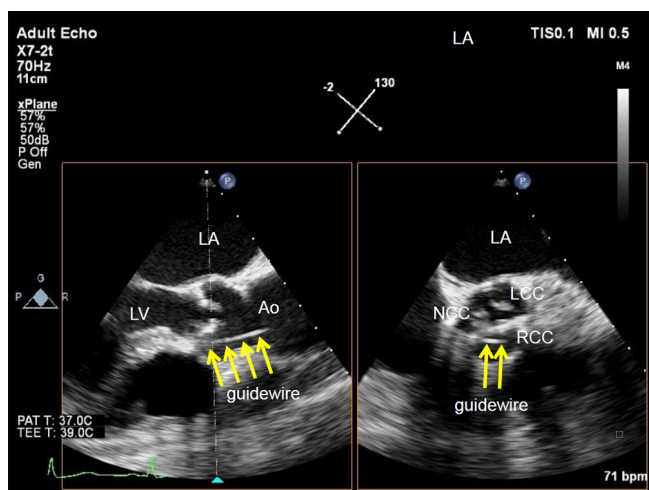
Wire insertion assisted by simultaneous multiplane imaging. Transesophageal echocardiography can demonstrate the location of a guidewire in the RCC of the aortic valve (yellow arrows), with long (left panel) and short axis views (right panel), using simultaneous multiplane imaging. LV, left ventricle; LA, left atrium; Ao, aorta; LCC, left coronary cusp; RCC, right coronary cusp; NCC, non-coronary cusp.
